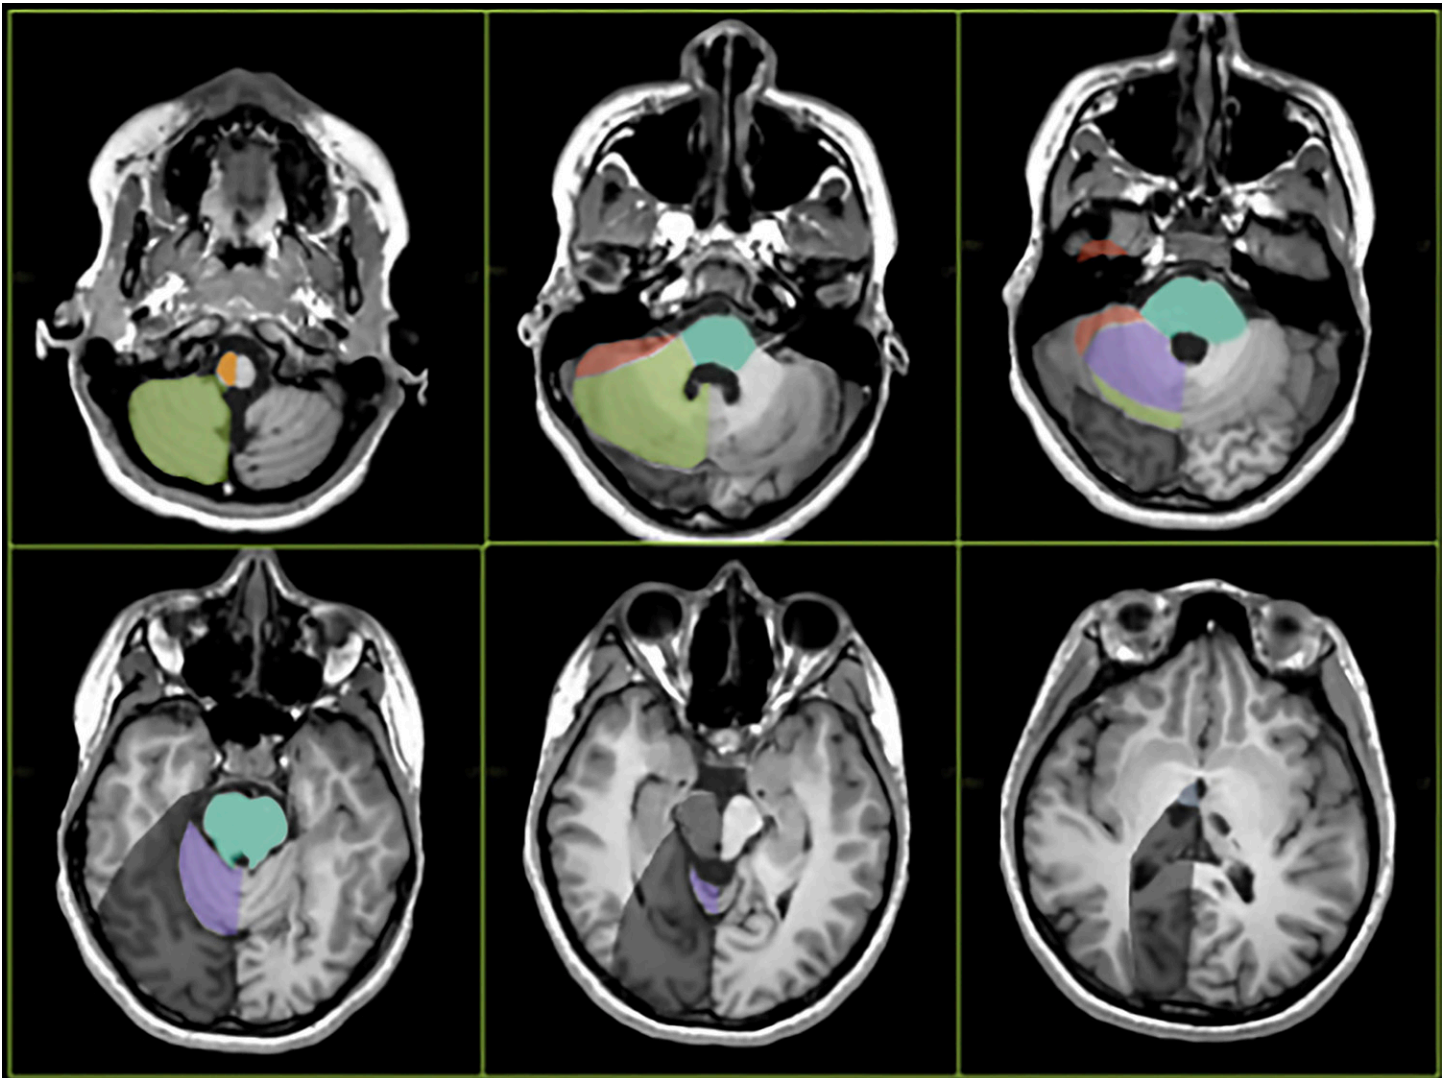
Axial T1-weighted MR images from inferior to superior (left to right) show the posterior circulation arterial blood flow territories. The vertebral artery territory is shaded orange; the basilar artery, teal; the posterior-inferior cerebellar artery, light green; the anterior-inferior cerebellar artery, red; the superior cerebellar artery, purple; and the posterior cerebral artery, dark gray.
